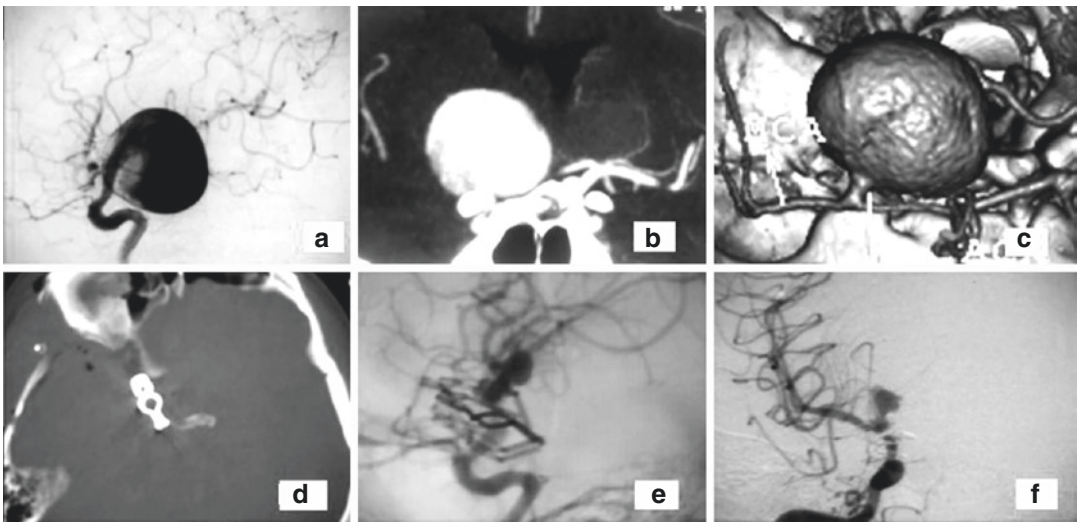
(a–c) Show 3D reconstructed images of a giant right supraclinoid aneurysm. (d), postop CT bone window with the clip. (e, f) Shows a small residue of the aneurysm post clipping
